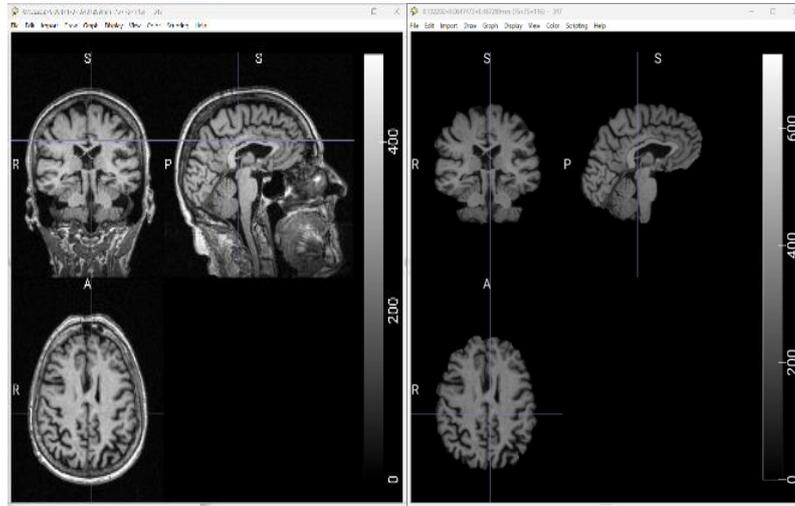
(a) Original brain MRI image before skull stripping using FSL-BET; (b) Brain MRI image after skull stripping processed with FSL-BET
